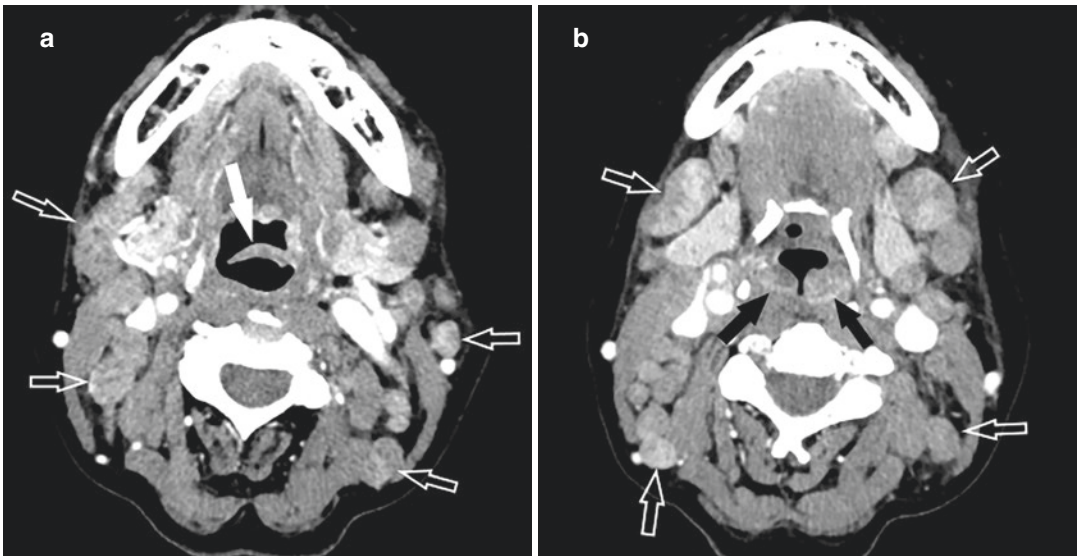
Nontuberculosis mycobacterial (NTM) laryngitis. (a) Axial contrast-enhanced CT image shows diffuse enhancement with thickening of the epiglottis (solid arrow) and multiple bilaterally heterogeneously enhancing lymph nodes (open arrows). (b) Axial contrast-enhanced
